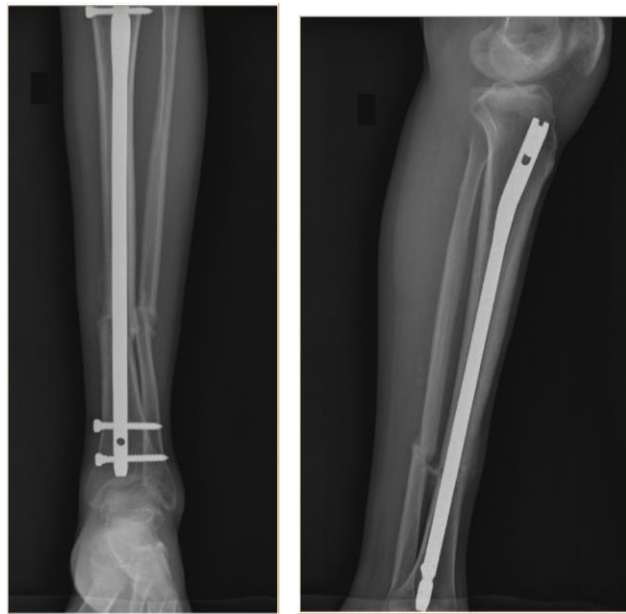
Immediate post-op radiograph
